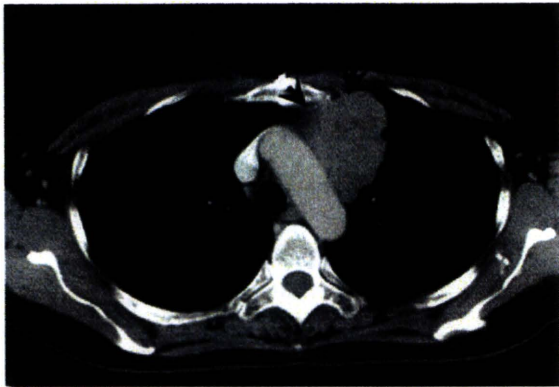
Computed tomography performed 29 years after the first surgery, showing a well-defined mass in the anterior mediastinum, adjacent to the aortic arch. The arrows indicate the margin of the tumor.
